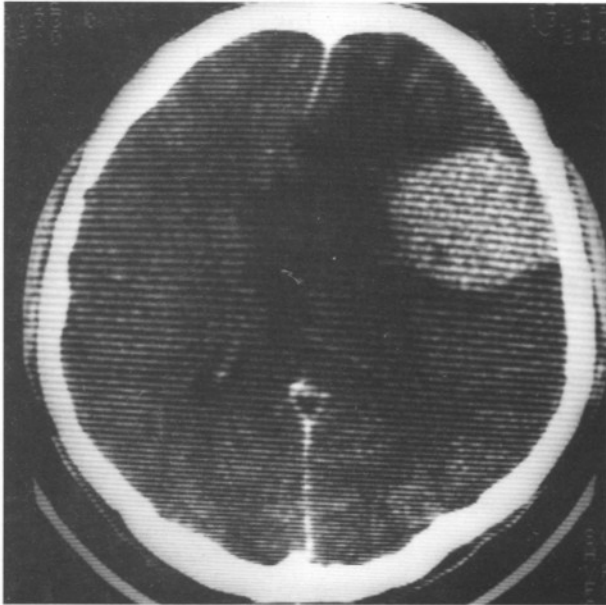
Post contrast CT scan shows a homogeneously enhancing left fronto-parietal round lesion (meningioma).
